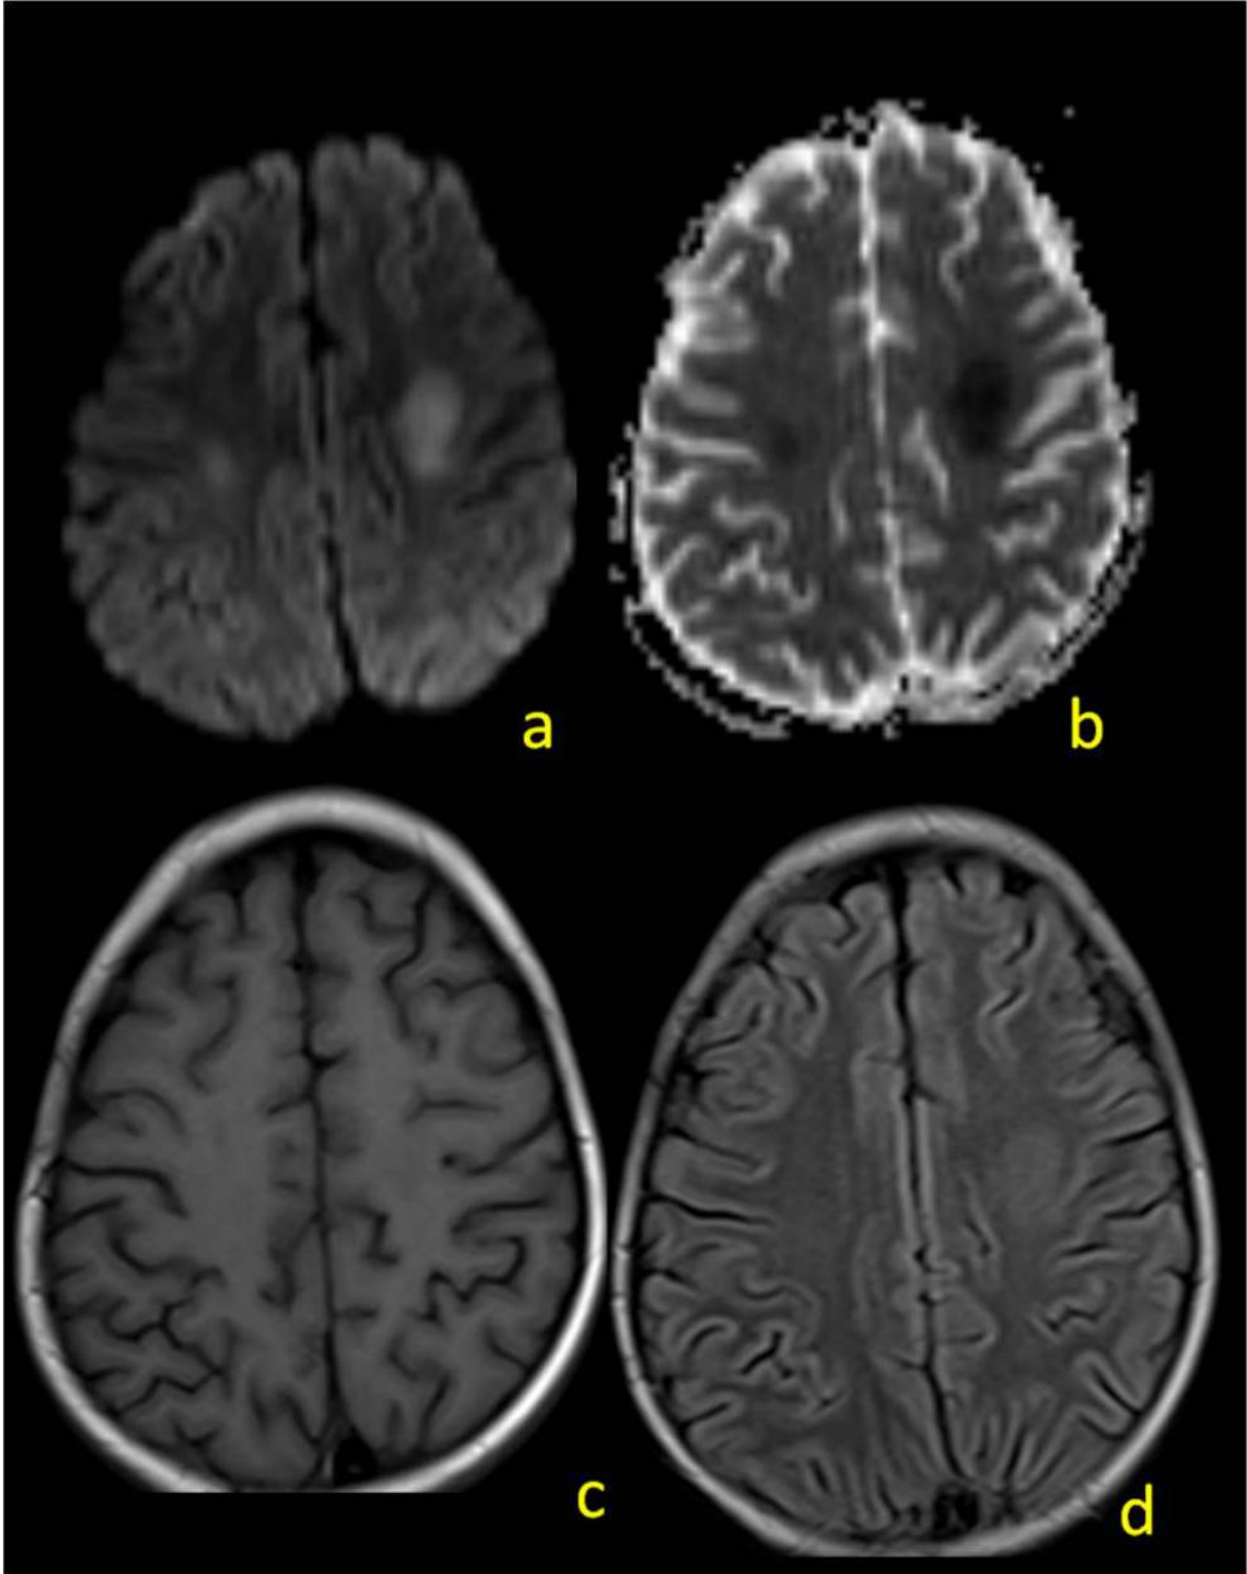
10 days later after Fig 5: the dark signal in ADC map was totally disappeared (a), DWI shows slight bright residue (b). The bright signal is now more appreciable (c), T1WI is still negative.
